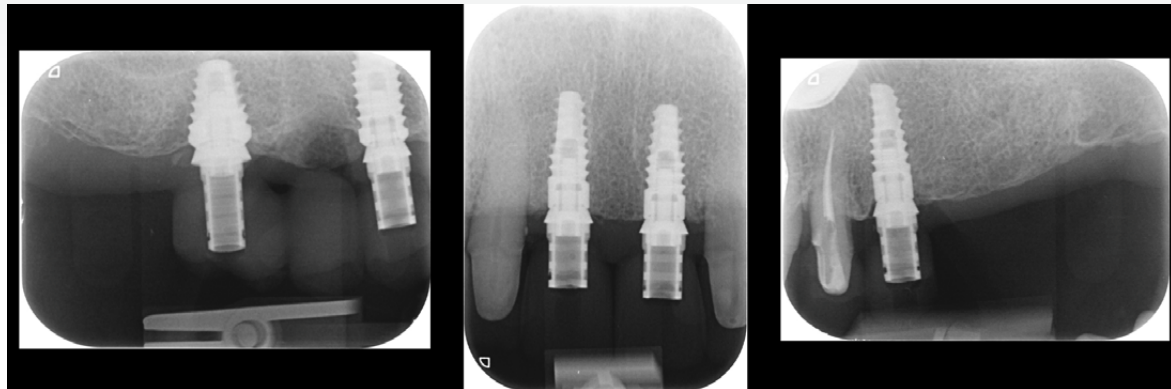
Periapical radiographs to verify the seat of the implant-retained provisional restorations.
